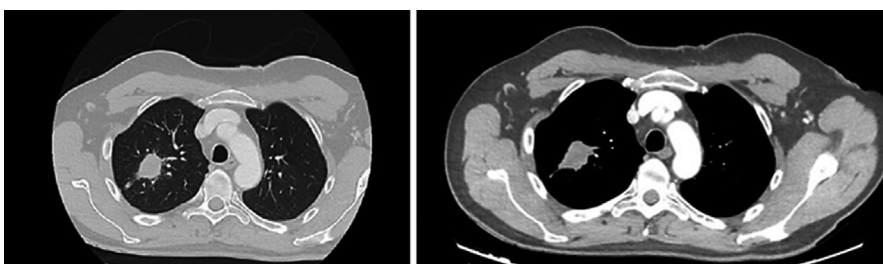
CT Chest demonstrating large mass in the right upper lobe of the lung along with some sites of distant metastasis
